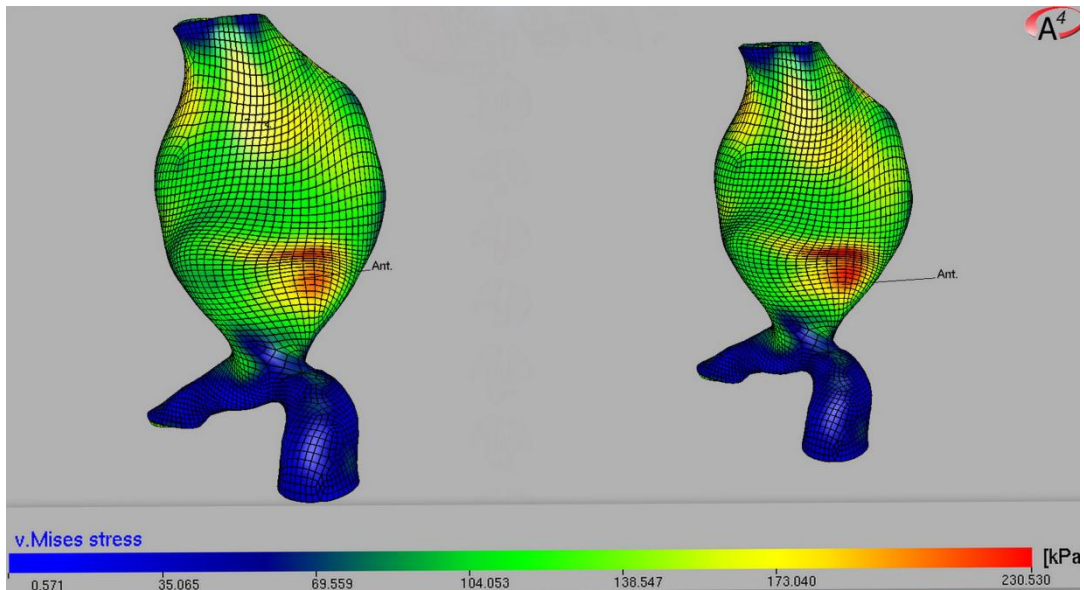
Wall (von Mises) stress distribution for AAA No.3. with the intact (left) and fissured (right) ILT model. ILT fissure were directly identified from CT-A images (direct fissure analysis).
